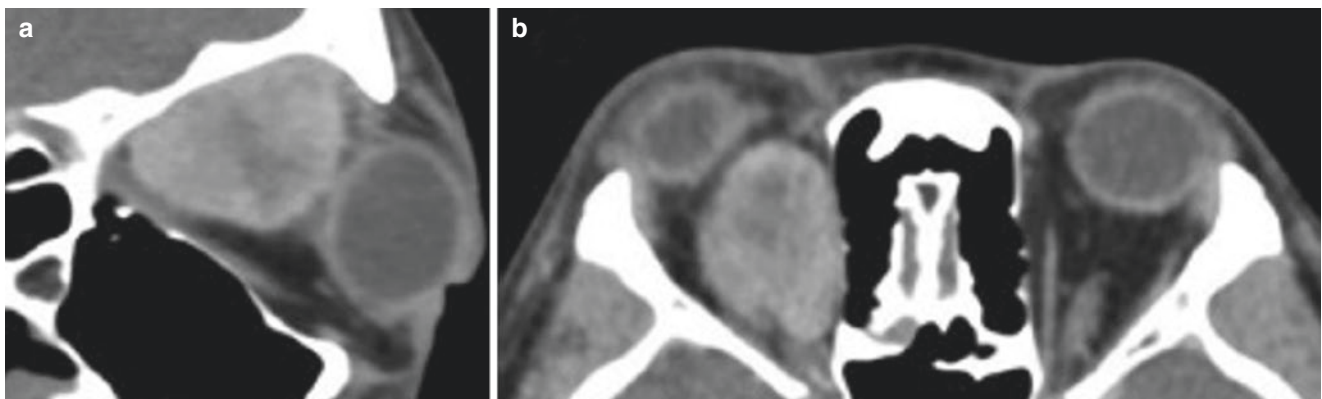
Sagittal (a) and Axial (b) CT orbits show a right heterogeneous, predominantly extraconal mass in superomedial orbital space with remodelling of the medial orbital wall
